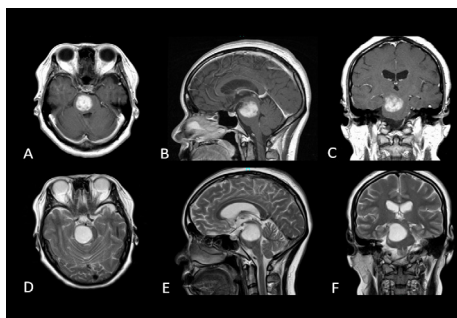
Brain MRI of case 2 before treatment. A, B: Contrast MRI. C, D: T2WI. A tumor is located from pons to midbrain.
